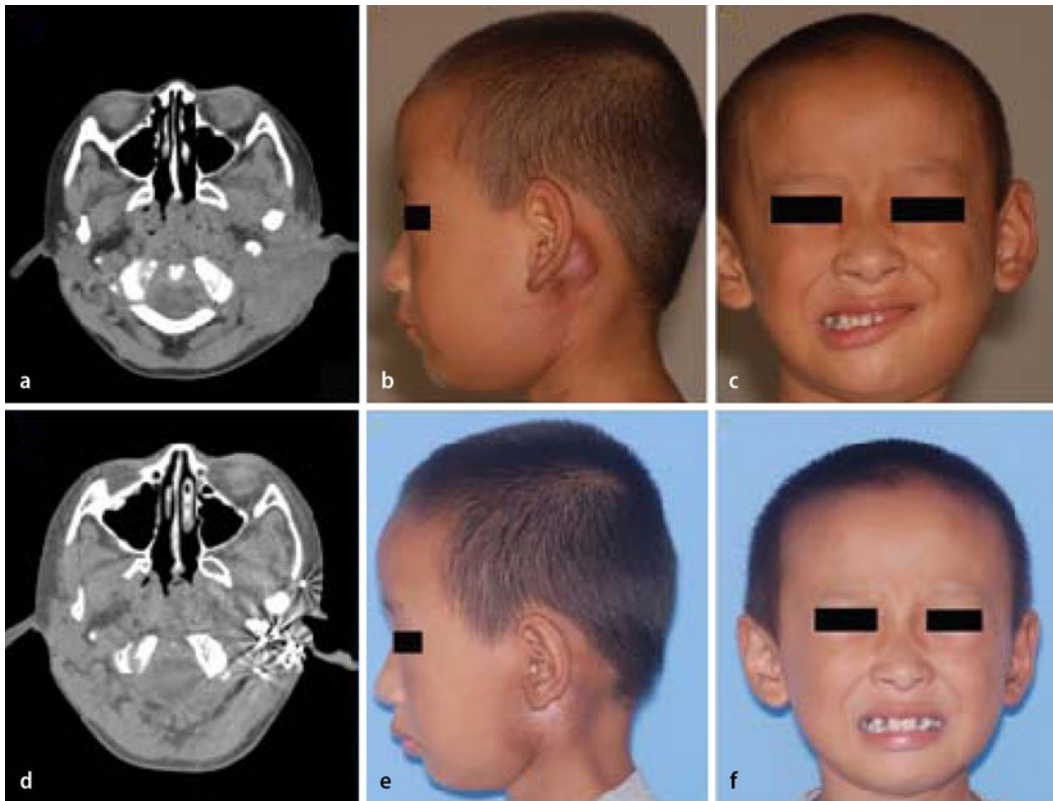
◀ a CT shows the tumor in the *left* parotid gland. b The profile shows the tumor has invaded the skin. c The picture shows this patient had weakness of the marginal branch of the facial nerve, corresponding to a H-B grade II paresis. d A typical transverse slice shows the distributions of the ^{125}I seeds of the patient underwent ^{125}I seed implant brachytherapy. e After 12 months, there were no serious complications in the local region and the skin of the *left* parotid gland recovered. f After 12 months, the patient who underwent ^{125}I seed implant brachytherapy recovered with H-B grade I
